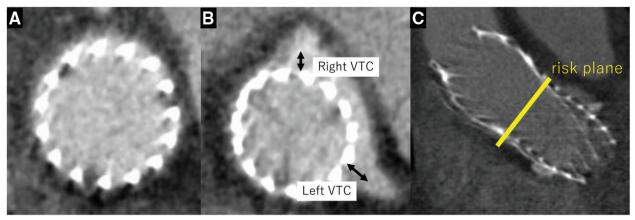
(A) Preoperative coronary CT revealed that the THV and the aortic wall were in contact with nearly the entire circumference at the ST junction. (B) Right VTC distance was 2.8 mm and left VTC distance was 3.8 mm. (C) Yellow line represents the risk plane that was defined as the level under which the stent frame of the initial TAV would be covered after its leaflets were displaced vertically with the implantation of a second TAV. CT: computed tomography; THV: transcatheter heart valve; ST junction: sinotubular junction; VTC: valve-to-coronary; TAV: transcatheter aortic valve
